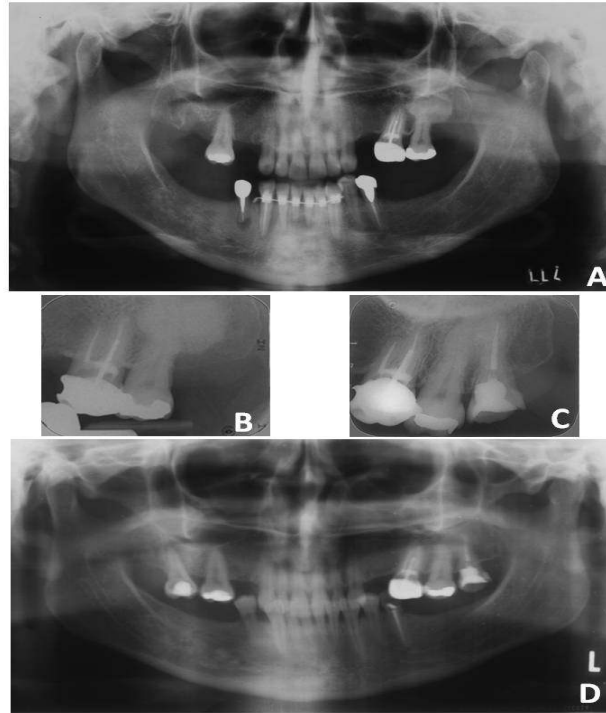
(A) Panoramic image showing a round, well defined, radiopaque mass attached to the root of the left maxillary second molar. (B) Periapical image allowing more detailed evaluation. (C) Periapical image showing widening of the periodontal ligament space. (D) Panoramic image showing the absence of a radiopaque mass attached to the left maxilla
